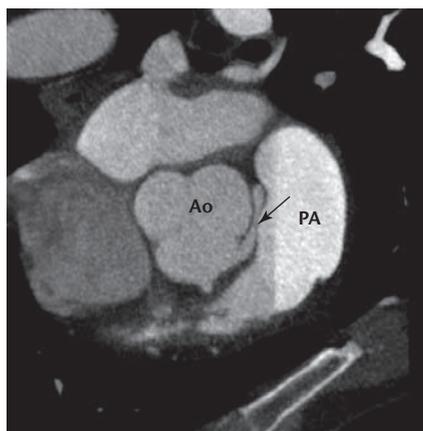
Cross-section on coronary computed tomography angiography demonstrating the course of the left main artery between the pulmonary artery (PA) and the aorta (Ao).
